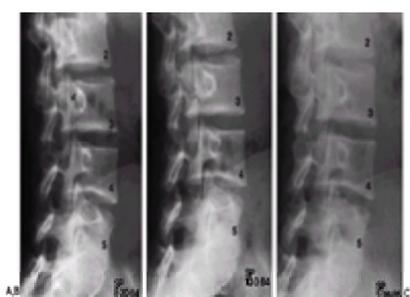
A: This high school soccer player was seen for mild, generalized low back pain. Physical examination and radiographs, including this oblique view, were normal. B: Two months later, 10 days after an acute back injury suffered during a soccer game, a pars defect at L3 is clearly visible. C: The patient was placed in an orthosis for 3 months, and 1 month later the lesion had healed, the symptoms had resolved, and the patient had returned to playing sports. (From ref. [45](#), with permission.)
